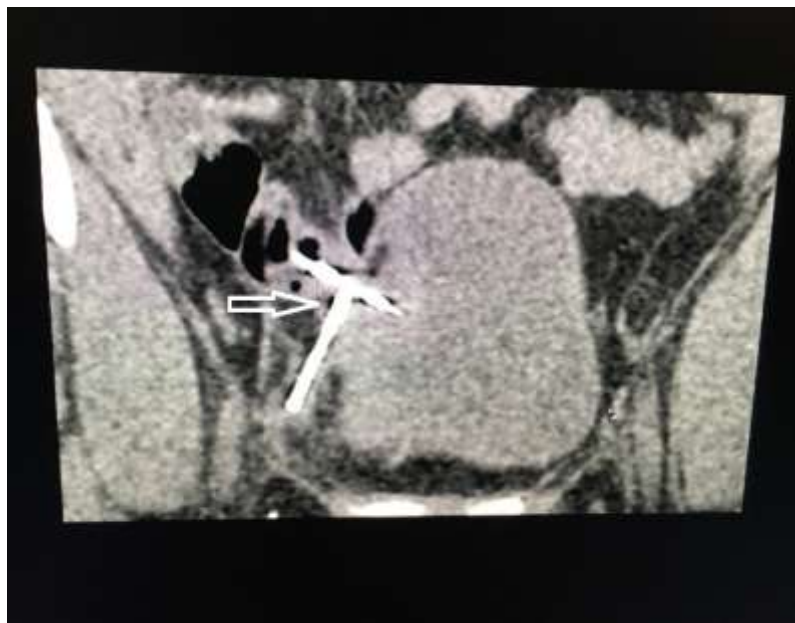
Showing CT image of simultaneous perforation of small bowel and right lateral urinary bladder wall (white arrow)
